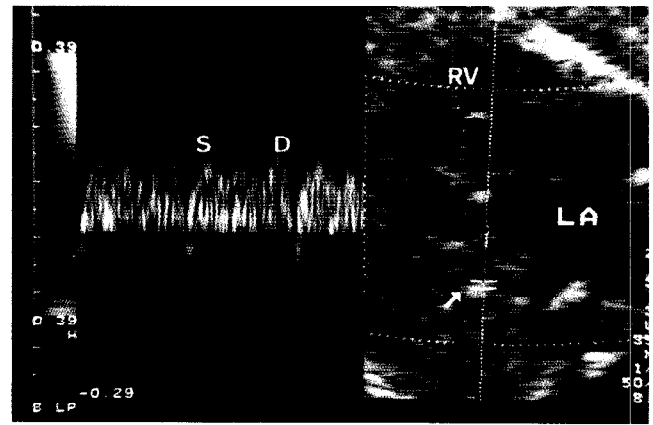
Pulmonary venous Doppler velocity waveform. The arrow indicates the site of intrapulmonary flow recordings (> 5 mm from the atrial wall). In some instances, as in this 26-week fetus, reversed flow at the time of the atrial contraction can be recorded. S, systolic peak velocity; D, diastolic peak velocity; LA, left atrium; RV, right ventricle
